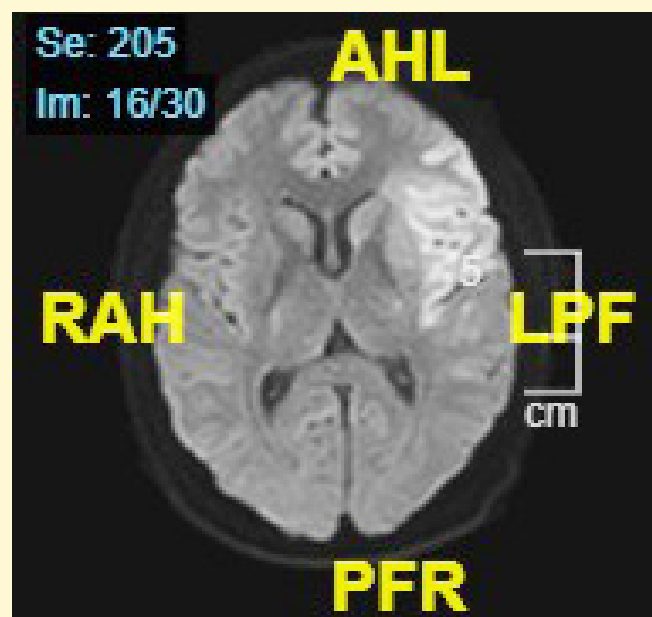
Diffusion weighted MRI image showing acute infarct in left MCA territory involving insular cortex and adjacent frontal and temporal operculum.
